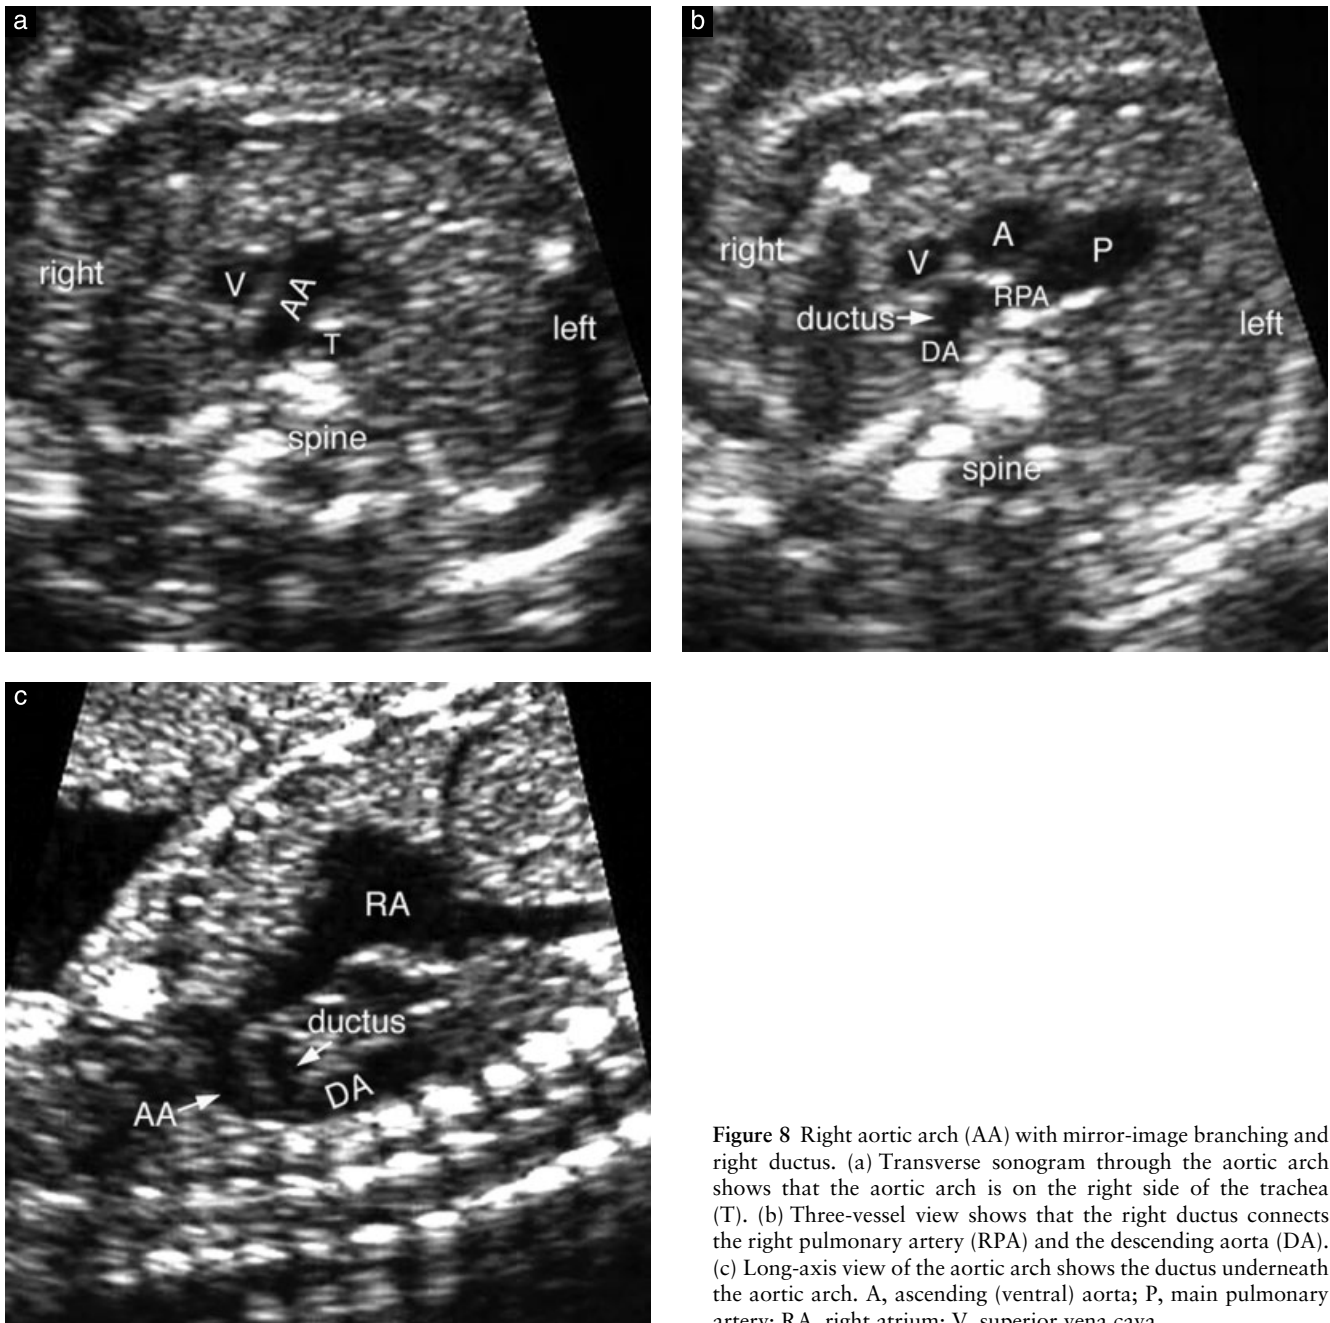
Right aortic arch (AA) with mirror-image branching and right ductus. (a) Transverse sonogram through the aortic arch shows that the aortic arch is on the right side of the trachea (T). (b) Three-vessel view shows that the right ductus connects the right pulmonary artery (RPA) and the descending aorta (DA). (c) Long-axis view of the aortic arch shows the ductus underneath the aortic arch. A, ascending (ventral) aorta; P, main pulmonary artery; RA, right atrium; V, superior vena cava.
